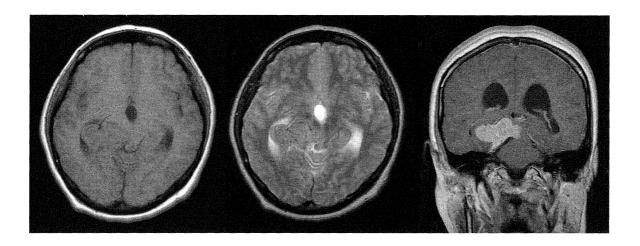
Brain MRI demonstrating a tumor with hydrocephalus on the cerebellar tent. The tumor was visualized as an isointensity signal on both T1-weighted image (left) and T2-weighted image (middle), and homogeneously enhanced on gadolinium-enhanced T1-weighted image (right).
